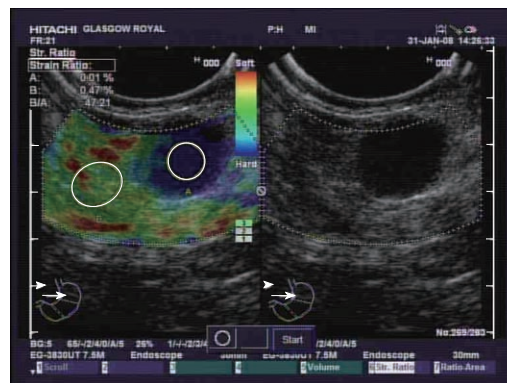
Endoscopic ultrasound image of a malignant appearing lymph node. The right-hand side of the image displays all 4 of the conventional endoscopic ultrasound criteria characteristics of malignant nodes with regard to size (> 1 cm), shape (round), density (hypodense) and distinction of border (clear edge). The left-hand side of the image is a superimposed elastographic image with strain ratio measurement between an area of the lymph node and a surrounding area of tissue.
